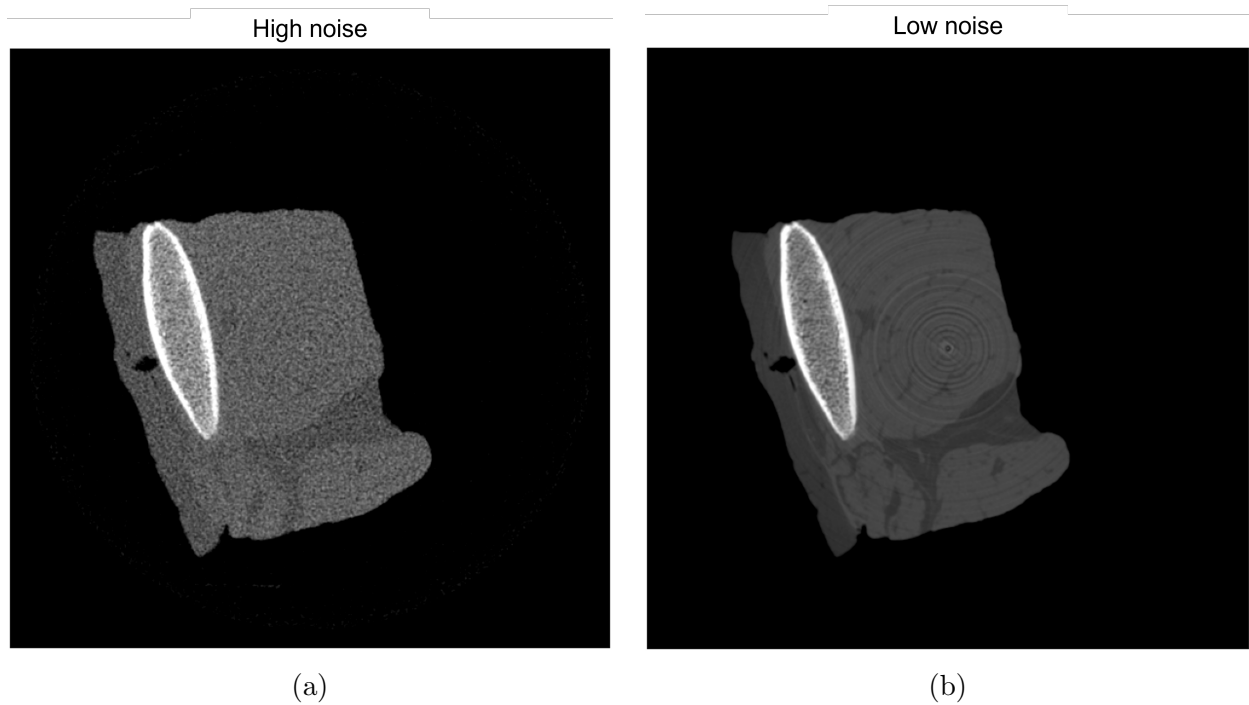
Image noise. CT slice of an *ex-vivo* tissue sample with (a) high image noise (b) low image noise.
